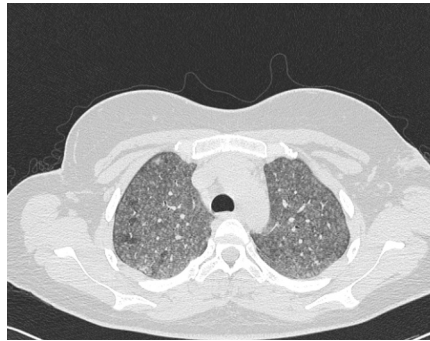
High resolution computed tomography scan of chest. Centrilobular ground glass appearance with darker areas of air trapping. Extrinsic allergic alveolitis.
